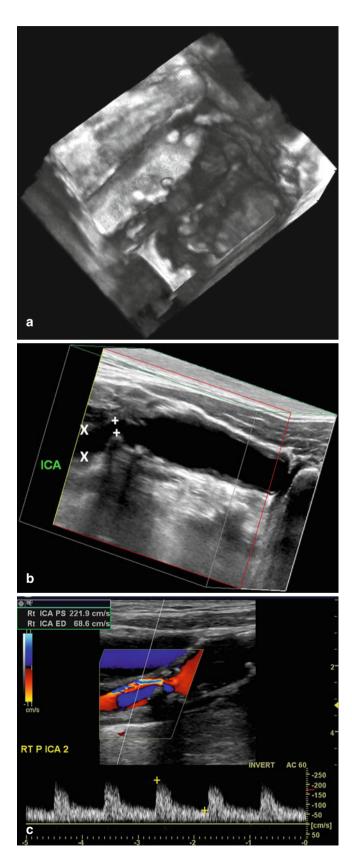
3D reconstruction of a carotid bifurcation region applying the NASCET methodology for stenosis measurement, with ultrasonic calipers on the internal carotid artery showing the minimal lumen diameter (X) and the distal ICA lumen diameter (+). Also note the small ulcerative crater at midlesion
